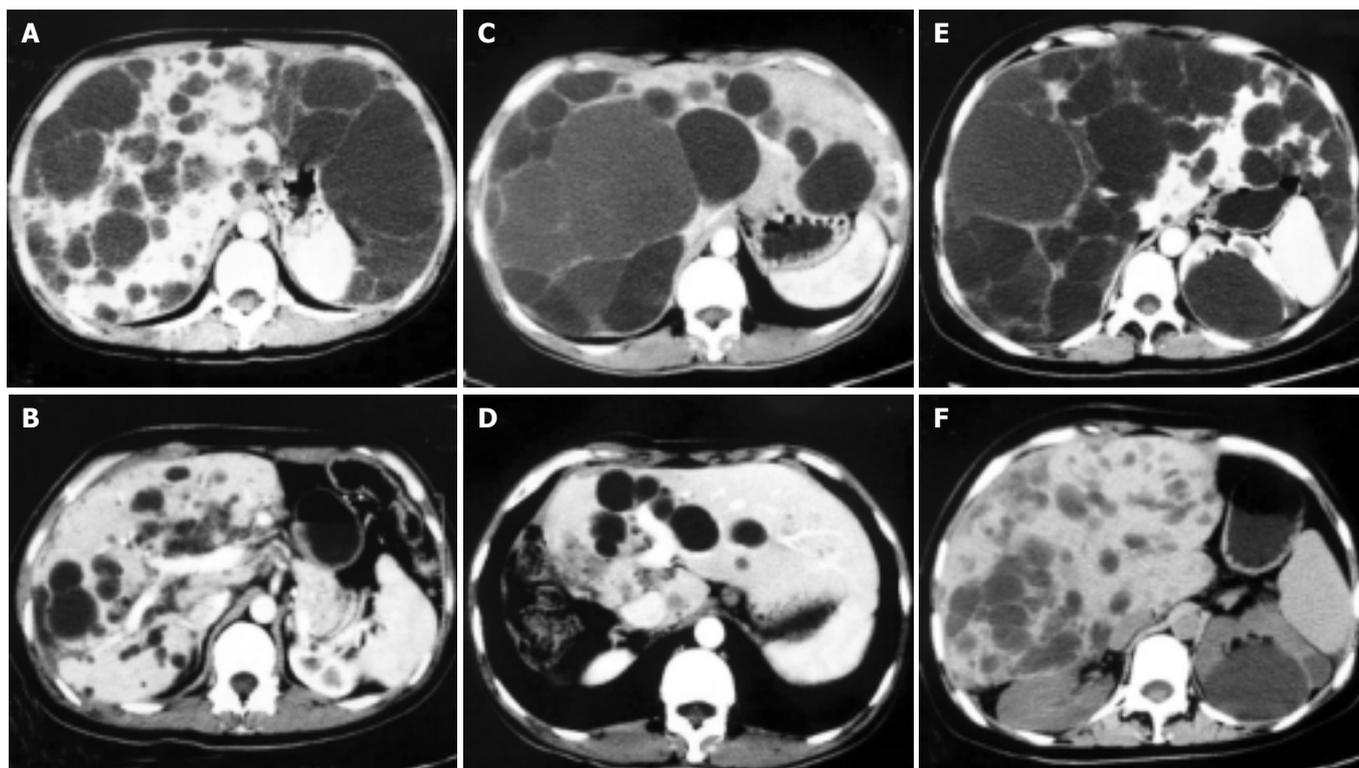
CT scans of livers in PLD patients before (left panels) and 3 mo (right panels) after operation, show that hypertrophy of spared liver and lack of clinically significant cyst progression, and that operative methods totally depend on cystic distribution in different patients, e.g., lateral segment removal from A to B, right semi-hepatectomy resection from C to D, whereas extensive fenestration of posterior and interior cysts from E to F.
